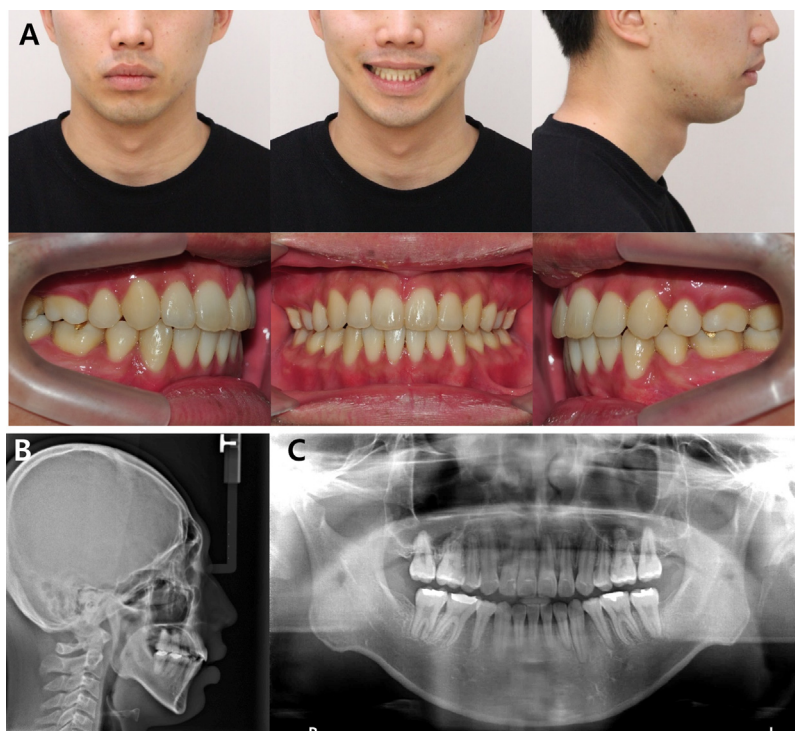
Case 2. Posttreatment data. A: Facial and intraoral photographs, B: Lateral cephalogram, C: Panoramic radiograph.
